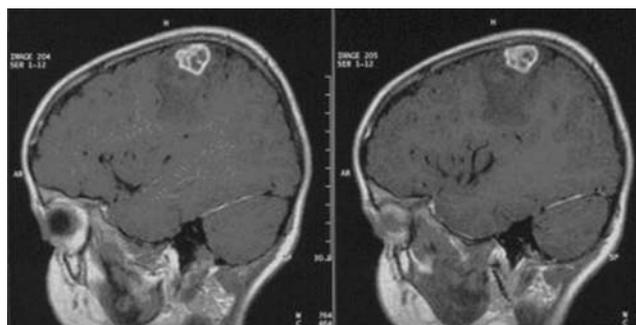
Brain magnetic resonance imaging (MRI) scan taken at day 3, showing a unifocal infection surrounded by a vasogenic oedema
